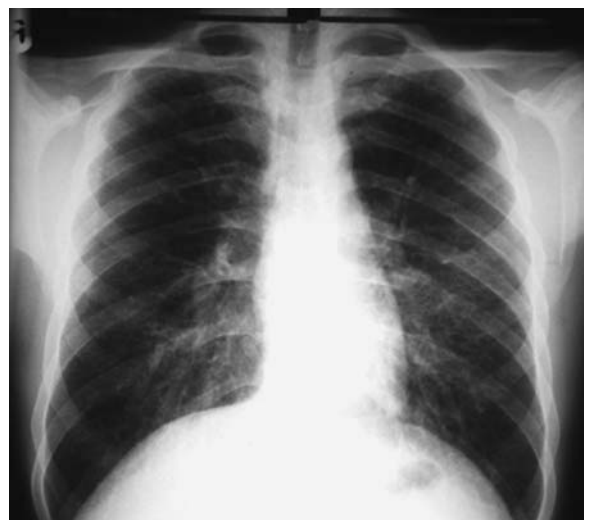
Chest radiograph in a young smoker with Langerhans' cell histiocytosis. There is a diffuse reticulo-nodular pattern in both lungs but, despite the apparently extensive disease, lung volumes are increased
